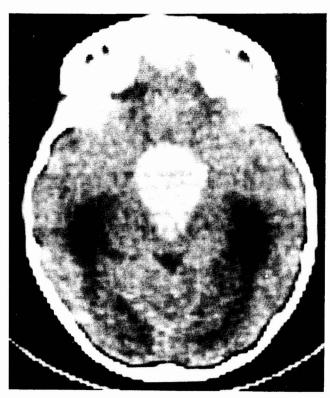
Our smallest craniopharyngioma (5 cm in vertical diameter) imaged on an unenhanced CT scan. Note hydrocephalus, the hyperdense tumor, and two sites of calcification.
